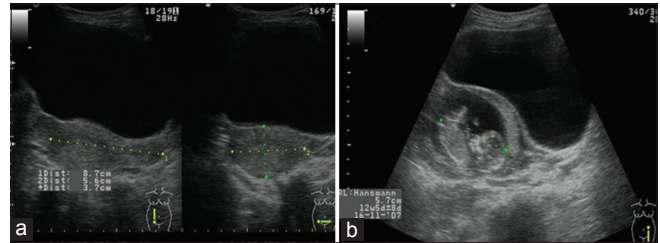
Ultrasound pelvis (Aloka SSD 4000, convex probe 5–2 MHz) shows normal uterus (a) measuring 8.7 × 5.6 × 3.7 cm and fetus with placenta of crown-rump length 5.7 cm corresponding to 12w5d seen in left adnexa posterior to the bladder. (b) There is no obvious myometrial rim surrounding the sac, hence difficult to comment regarding the origin of ectopic pregnancy
